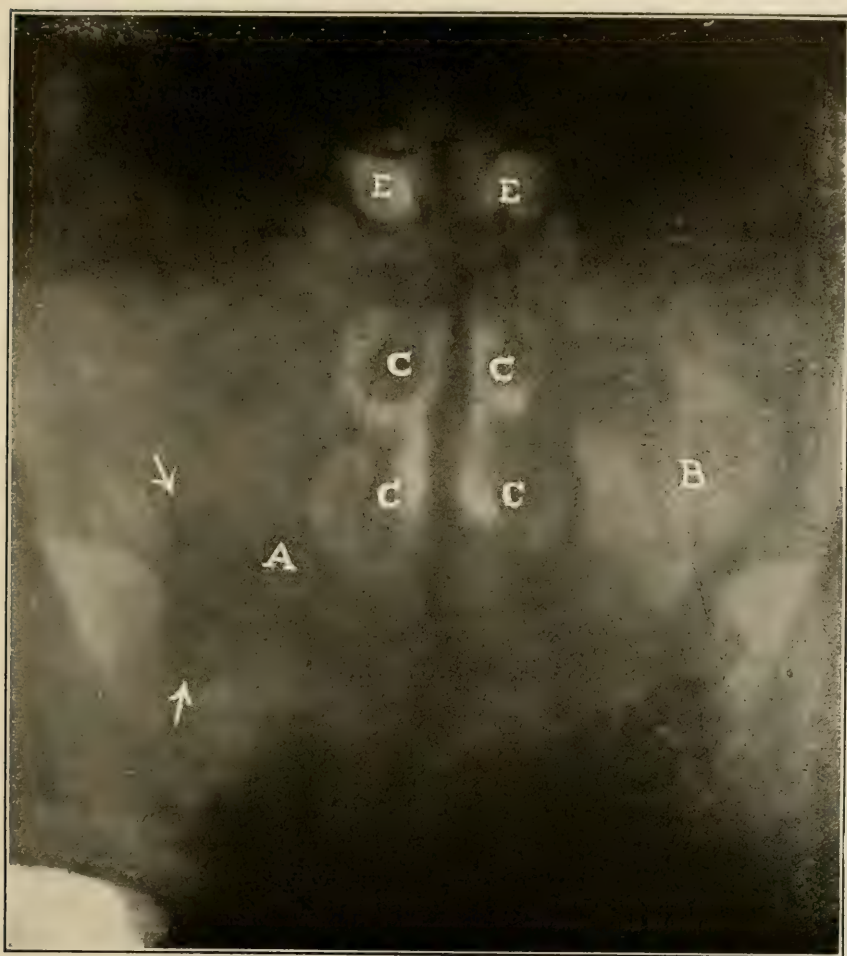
A, diseased antrum. The shadow pointed to by the arrows is an impacted third molar. B, healthy antrum, CC, turbinate bones, EE, very small frontal sinuses. (Radiograph by Pfahler of Philadelphia.)
